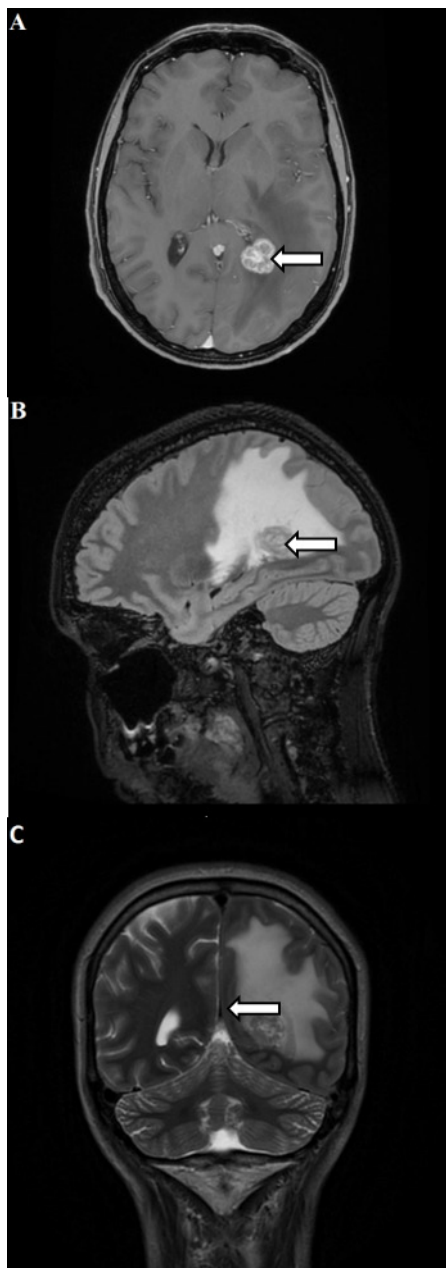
T1-weighted horizontal (A), T2-weighted sagittal (B), and T2-weighted coronal (C) MRI images of a 17 x 19 mm polycyclic contour lesion in the left occipital lobe, paraventricularly to the dorsal horn (arrow), with perifocal edema.
